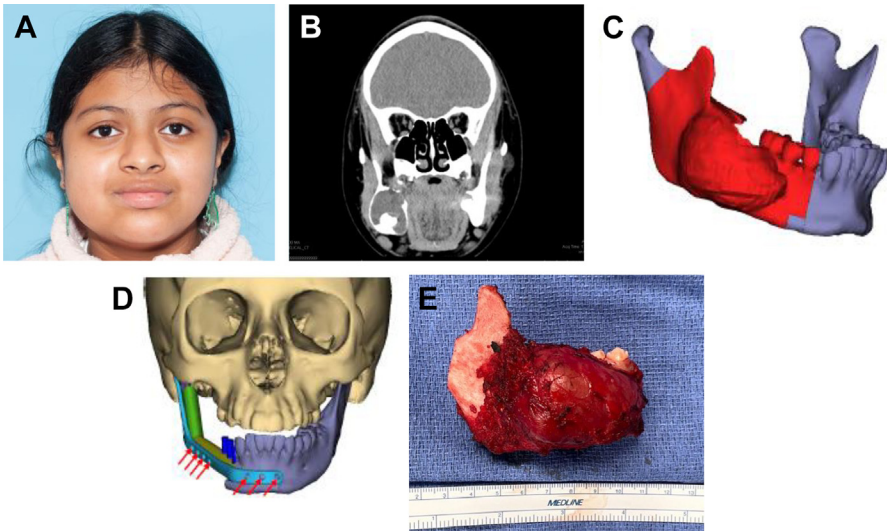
Mandible. (A) Preoperative photo. (B) Soft tissue coronal CT scan demonstrating large cystic mass in right hemi mandible. (C) Virtual surgical planning images showing planned resection (red). (D) Virtual surgical planning with custom plate (teal), fibula segments (yellow and green), and dental implants (blue posts). (E) Tumor extirpation after segmental mandibulectomy, lateral view, with clear margins on frozen examination.
